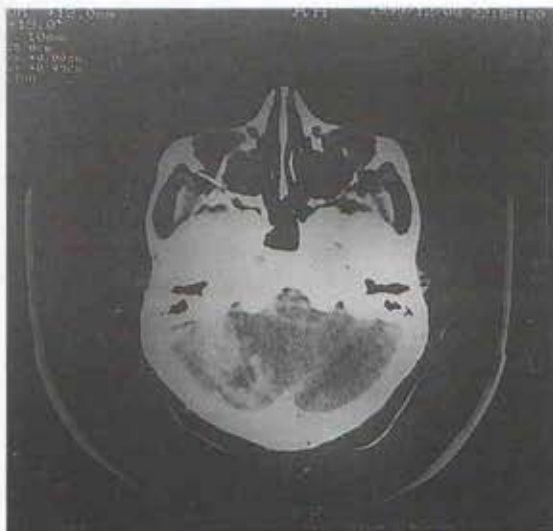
CT scan fragment of case 2.
